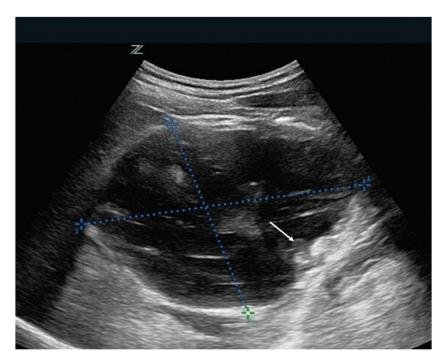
On the ultrasonograpgy, nodular enhancement was appreciated at the cyst wall, which revealed malignancy of the mass.
